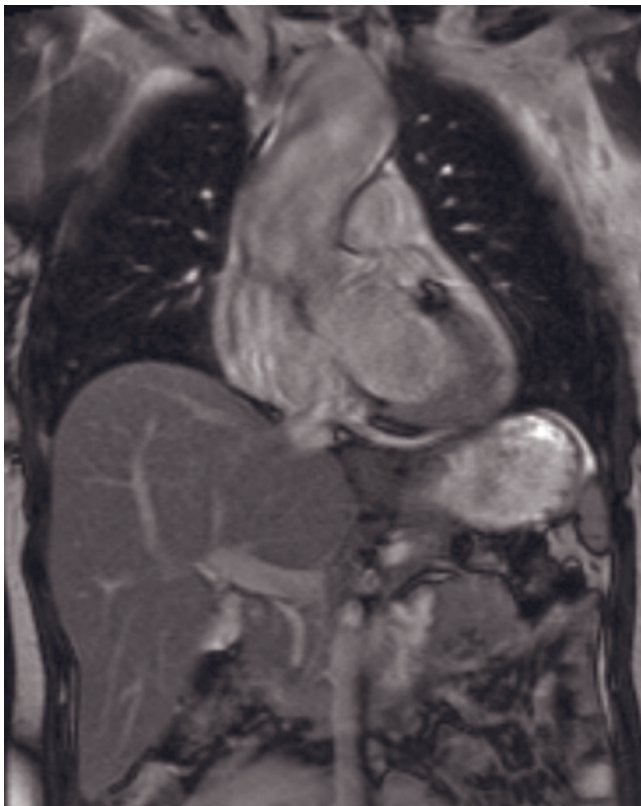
(*Continued*) Patient 2 has diffuse atherosclerotic changes and saccular aneurysm originating from the inferior surface of the aortic arch, and patient 3 has a pseudoaneurysm of the ascending aorta (arrows, *d*, *e*). The large vessels of the thoracic aorta are optimally studied with MRA employing a dynamic gadolinium-enhanced MRA technique. It is always essential to look at the source images (*c*) in addition to the reconstructed images (*d*), and it is quite often useful to perform MPR reconstructions in additional planes (*e*), especially for smaller vascular abnormalities. Sagittal 3D reconstructed MIP image (*f*) and coronal T1-weighted postgadolinium fat-suppressed 3D-GE image (*g*) demonstrate saccular aortic aneurysm (black arrow, *f*; curved arrow, *g*) originating from the inferior surface of the aortic arch and diffuse atherosclerotic changes in another patient. Coronal (*b*) and sagittal (*i*)
